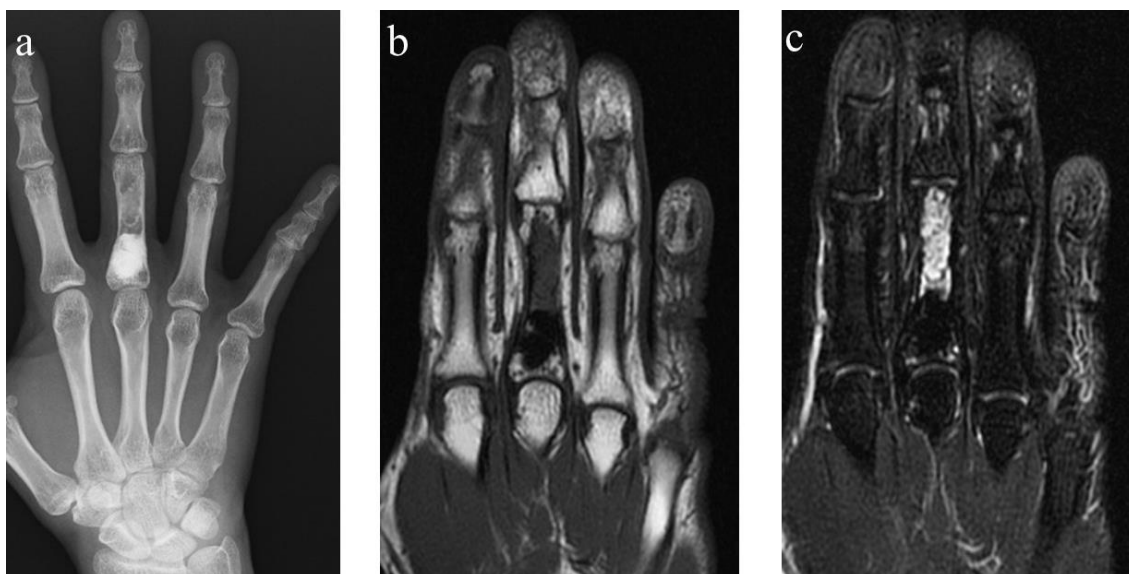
A-P radiograph (a) and MRI (b; T1 weighted image and c; T2 weighted image) at the referral visit to our hospital
